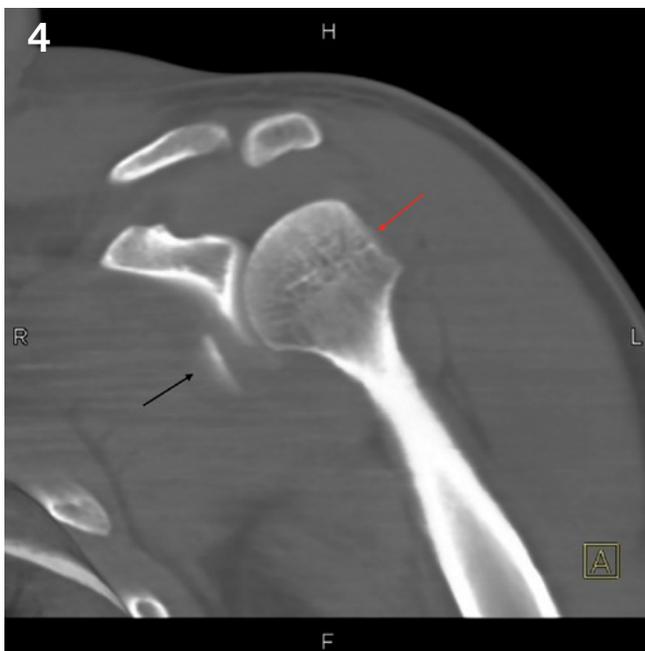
Coronal CT image demonstrating Hill Sachs deformity of the posterolateral humeral head (red arrow) and Bankart lesion in the anterior/inferior glenoid (black arrow).
